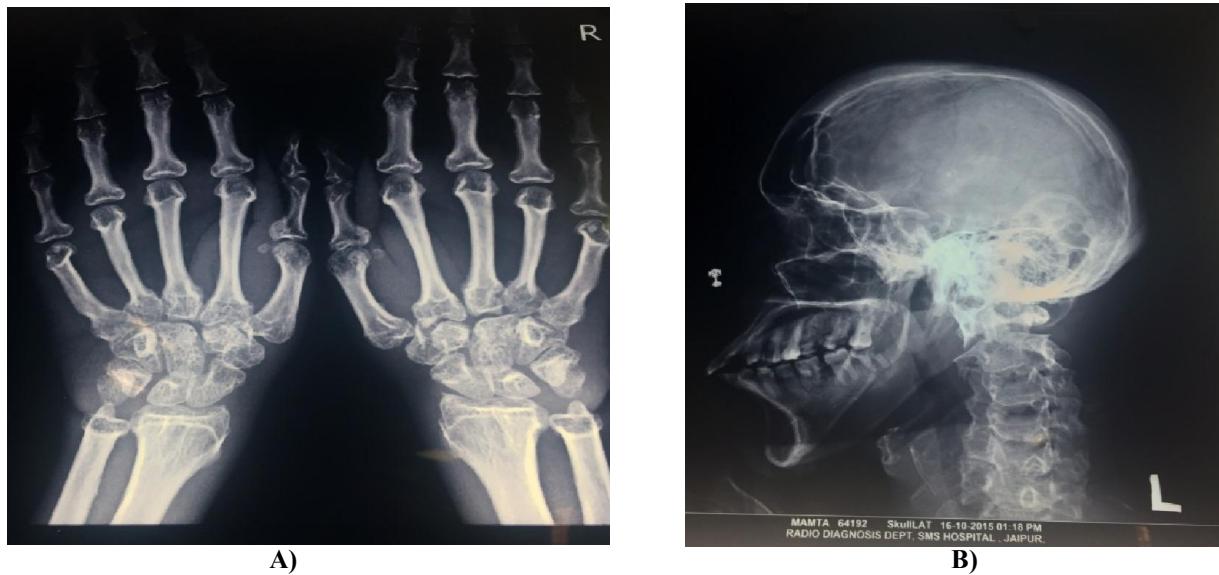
A) AP radiography of the hand- Shows ungual tufting, widening of bases of distal phalanges, and metacarpal osteophytes on radial aspect
